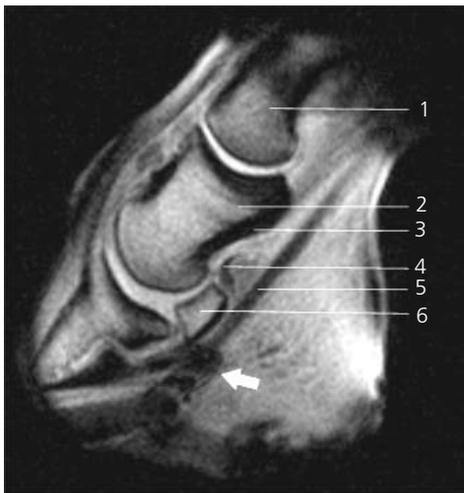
T1-weighted sagittal image of Case 3 of the foot 5 mm medial to midline taken 2 days post injury. A large area of hypointensity (white arrow) crosses the digital cushion and the medial DDFT. 1 = Proximal phalanx; 2 = medullary cavity/trabecular bone of middle phalanx; 3 = cortical bone of middle phalanx; 4 = collateral sesamoidean ligament; 5 = deep digital flexor tendon; 6 = medullary cavity of navicular bone.
